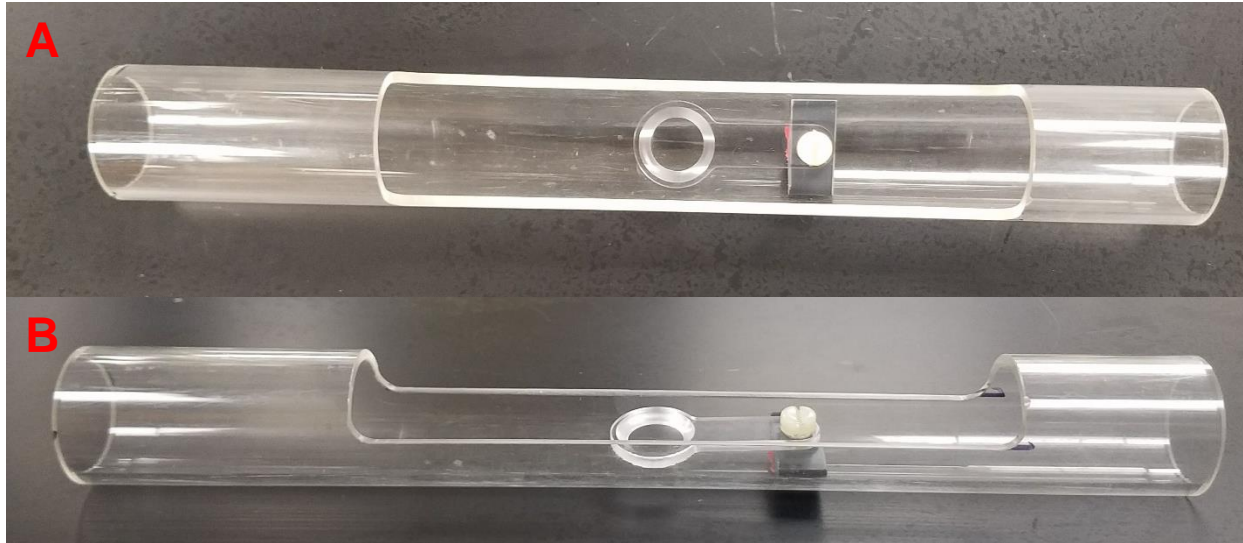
The device built for placing the instrumented eye into an MRI machine for precise imaging of thermistor location. A) A top-down view of the MRI holder. B) An oblique view of the MRI holder.
